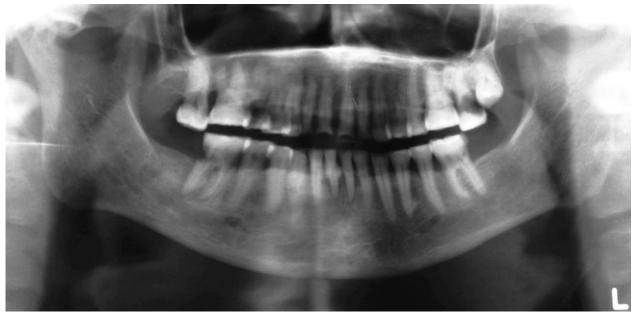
Panoramic radiograph demonstrating universal attrition of the permanent dentition. Note the extensive flattening of incisal and occlusal surfaces.
